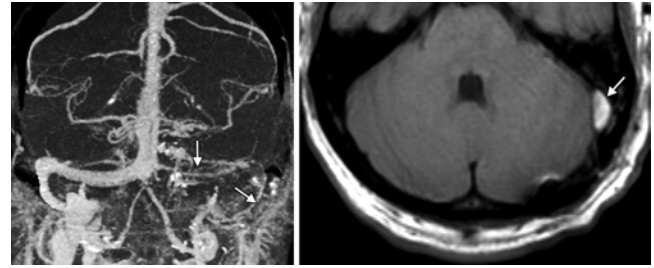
Venous sinus thrombosis. Left: Axial T1-weighted MRI study obtained after left retrosigmoid resection, showing intrinsic high signal within the left sigmoid sinus. Right: Corresponding 3D maximum intensity projection MRV showing a paucity of flow-related enhancement in the left transverse and sigmoid sinuses (arrows).
